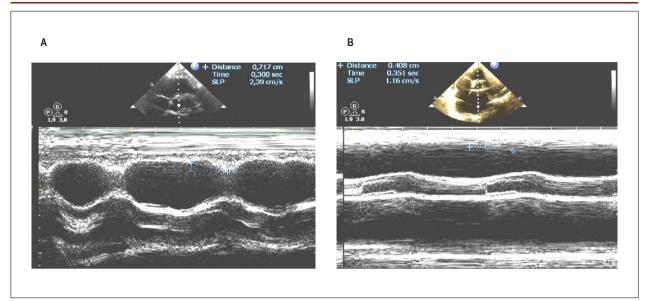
Right ventricular outflow tract systolic excursion (RVOT\_SE) was calculated by using M-mode echocardiography in the RV outflow tract (RVOT), from parasternal short-axis view at aortic valve level, measuring the excursion of the endocardial surface of the posterior wall of the RVOT. A: Normal RV systolic function (RVOT\_SE = 7.17 mm); B: Depressed RV systolic function (RVOT\_SE = 4.08 mm).
